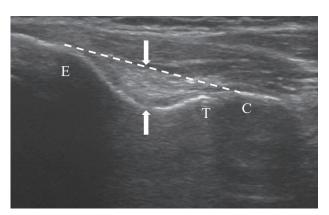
Ultrasound image of the long axis of the anterior bundle of the ulnar collateral ligament (UCL).
